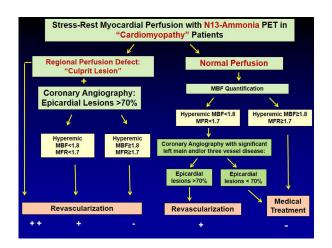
Algorithm for the integration of ¹³N-ammonia PET/ CT perfusion images, hyperemic MBFs and MFR in individuals with cardiomyopathy. Since in patients without cardiomyopathy or normal left ventricular function, a stressinduced regional perfusion defect signifies the "culprit" or most advanced CAD lesion, while hyperemic MBF and MFR may signify flow-limiting effects of lesions >70% diameter stenosis in patients with ischemic cardiomyopathy. Normal perfusion imaging, however, may not exclude diffuse ischemia due to significant left main and/or three-vessel disease. While normal hyperemic MBFs and MFRs may widely exclude highrisk CAD, this is not the case for abnormal hyperemic flows. Abnormal hyperemic MBFs may reflect diffuse microvascular function or diffuse ischemia in cardiomyopathy patients. In this setting, the additional wall motion analysis of the left ventricle at peak stress is not likely to be of much help as left ventricular function is severely reduced in most patients, and a further significant drop in left ventricular ejection fraction is not to be expected due to ischemic conditioning or cardioprotective effects. Thus, given normal perfusion but abnormal hyperemic MBFs in cardiomyopathy patients, invasive or noninvasive coronary angiography may be considered to triage these high-risk patients to coronary revascularization procedures or medical treatment alone.
